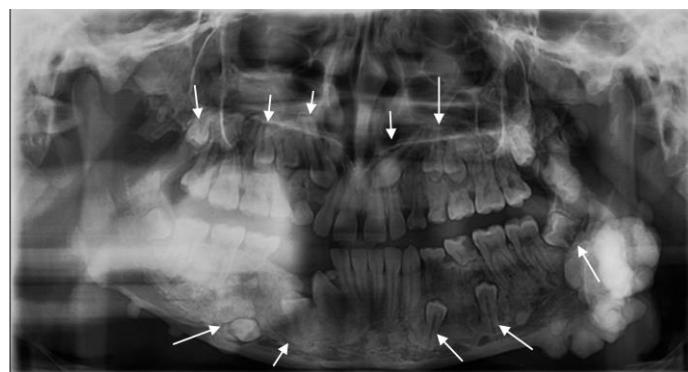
Panoramic radiograph shows multiple impacted teeth
